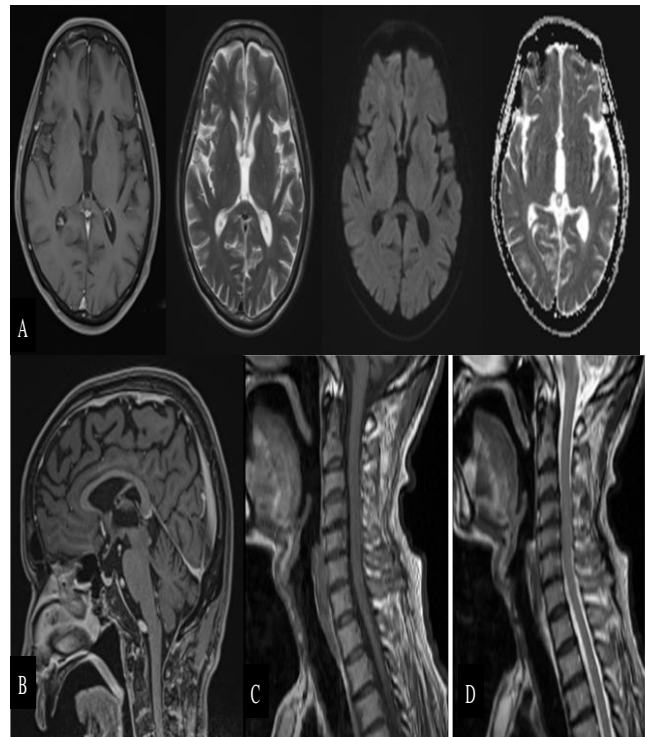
(A-D): Cranial MRI images at the level of internal capsule (T1, T2, DWI and ADC sequences in order) showing normal brain parenchyma. Post-contrast sagittal MRI of the brain, T1 sequence sagittal MRI of cervical spine, T2 sequence sagittal MRI of cervical spine.
